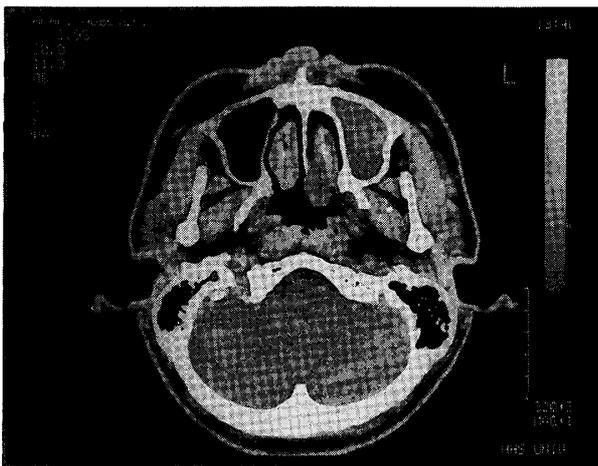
Computed tomograph before the operation. The left maxillary antrum is filled with a high-density mass.
